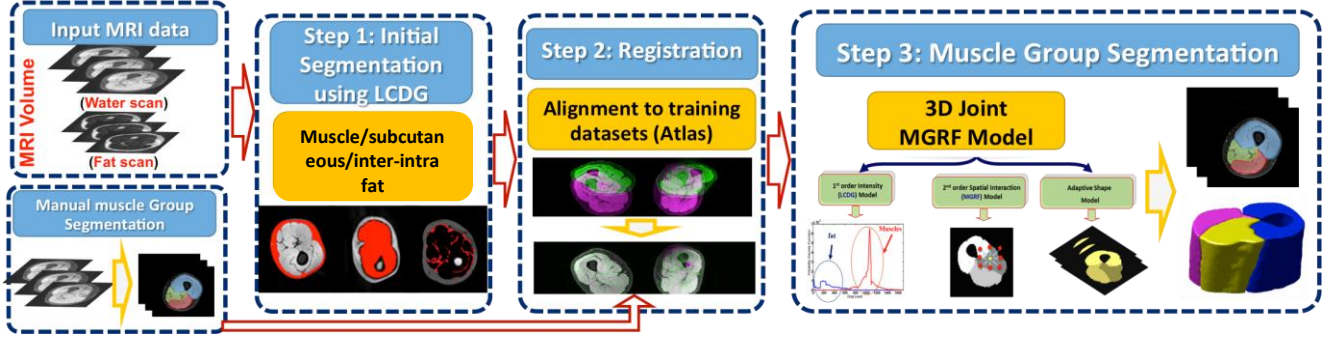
The proposed framework for muscles/fat analysis on MRI volumes.
